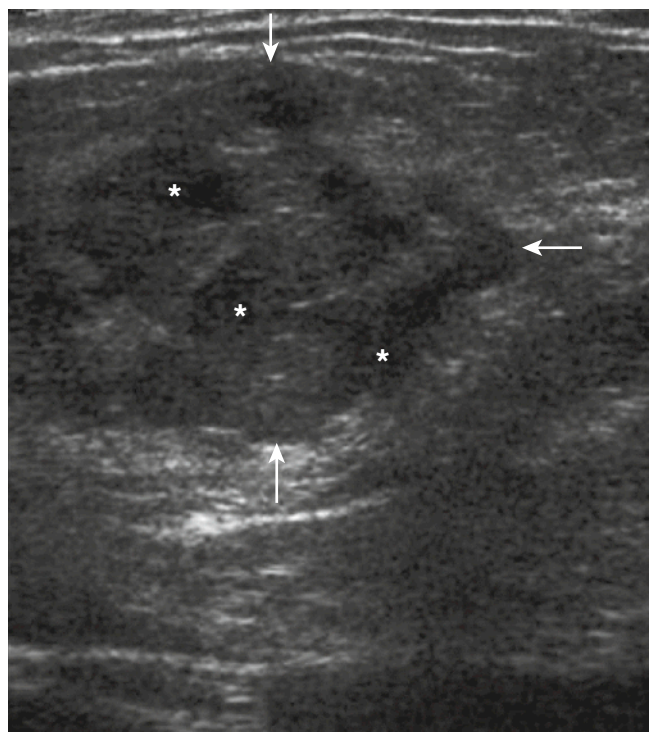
Transverse sonogram shows the margins of an abscess (arrows) containing loculated fluid (stars).
